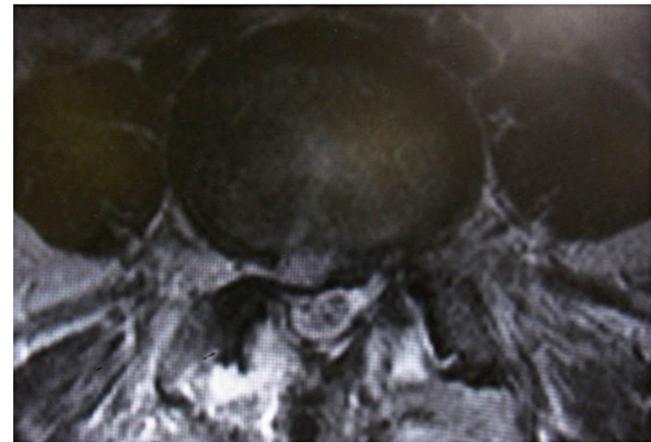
After second operation, MRI showed herniation was disappeared.
